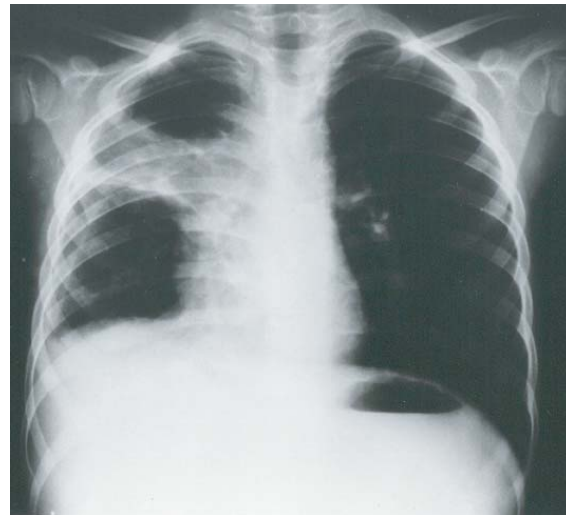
Chest radiograph following two months of antituberculous treatment.
